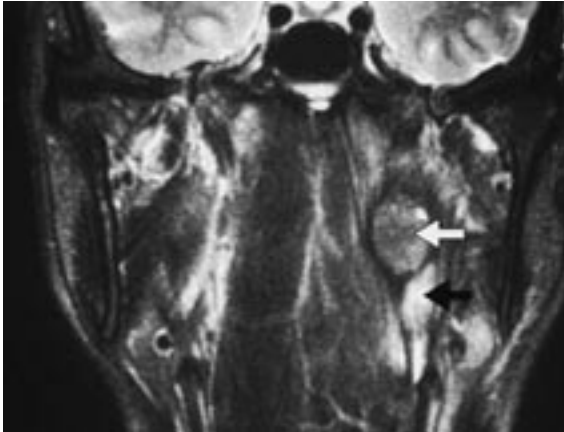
Coronal T2-weighted MR image shows the enlarged SCSG exhibiting low signal intensity (white arrow) compared to the high signal intensity of adjacent metastatic lymph nodes (black arrow) in the left neck.
